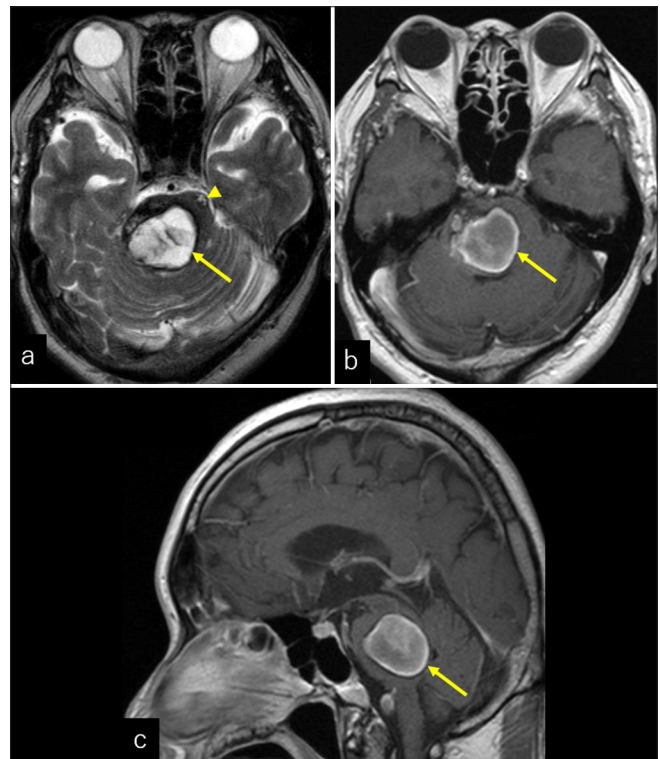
(a) Axial T2-weighted and contrast-enhanced (b) axial and (c) sagittal T1-weighted cerebral magnetic resonance images showing a less-enhancing mass occupying the dorsal pons, predominantly on the right side. It appears heterogeneous intensity and is accompanied by a hypointense rim (a-c, arrow). There is another lesion, suggesting cavernous malformation, identified in the left ventral pons (a, arrowhead).
